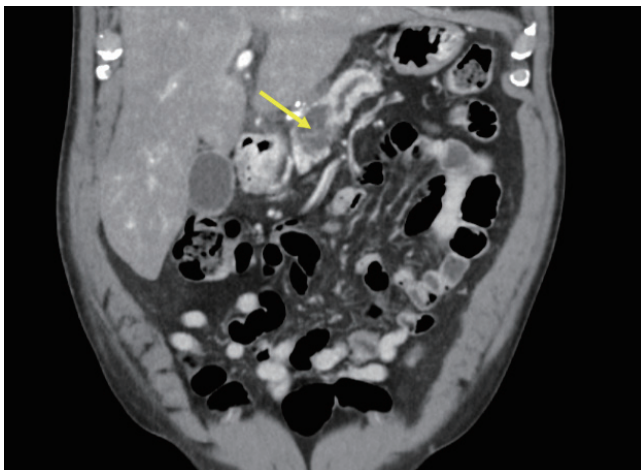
Coronal, contrast-enhanced CT image in portal venous phase demonstrates a cystic lesion measuring 2.9 cm in the pancreatic neck with thin septations (arrow) and mild pancreatic duct dilation up to 5 mm. The patient is a 71-year-old male who underwent endoscopic ultrasound with fine-needle aspiration based on this imaging. The pathology is consistent with mucinous cystic neoplasm, and no high-grade atypia is identified.
